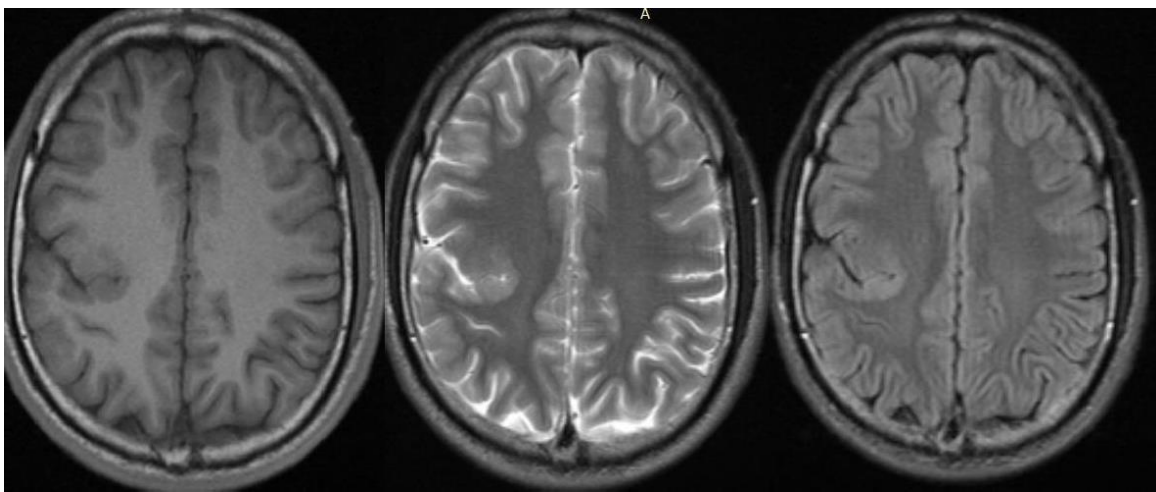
MRI brain axial T1WI (a), T2WI (b) and FLAIR (c) sequences showing irregular and uneven polymicrogyria along the right sylvian fissure.
